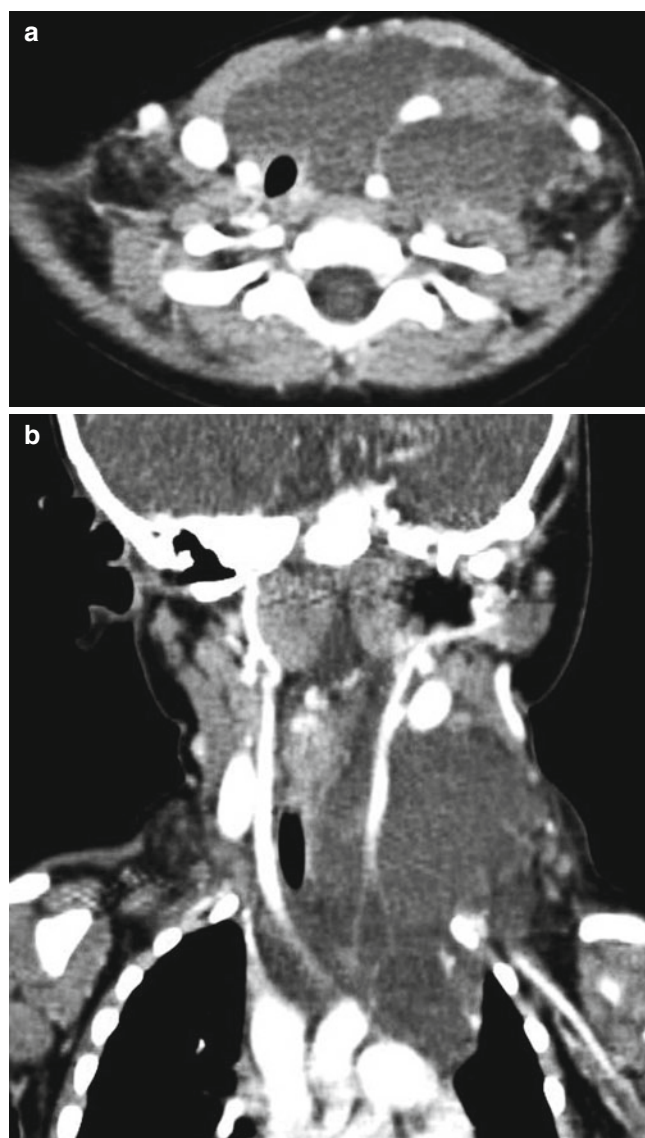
Lymphangioma in a 10-month-old infant. (a, b) Contrast-enhanced axial and coronal CT scans show a huge, multilocular cystic mass involving the pretracheal and posterior deep cervical spaces with fluid–fluid levels and extending to the mediastinum. Note the mass insinuating around the vessels
